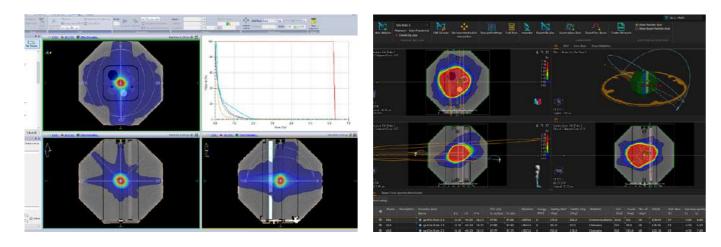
Treatment plans calculated on the CT dataset of the RUBY with System QA insert
